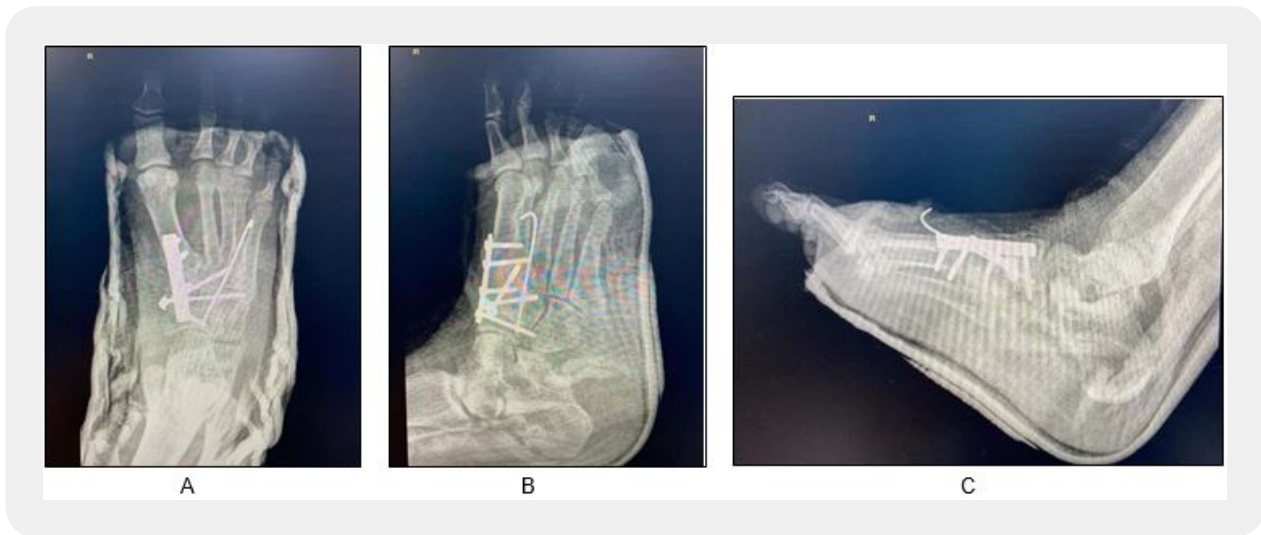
A, B & C Post-operative AP, oblique and lateral views x-rays of right foot with back slab showed reduced medial cuneiform dislocation and internal fixation
